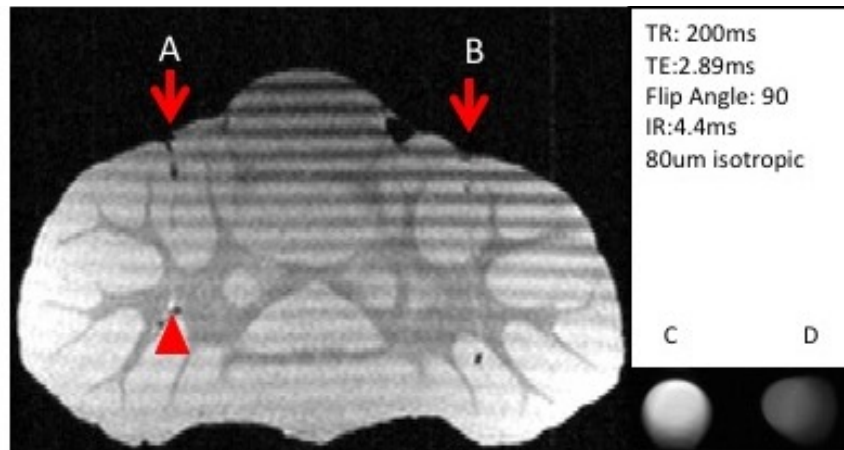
Ex vivo MRI of fixed HEK cells injected in to post mortem tissue. HEK cells expressing OATP (A) and infected with sham virus (B) were incubated in Primovist, before being fixed, washed and then injected in to a pre fixed cerebellum. The cerebellum was then imaged, ex vivo, as previously described. The syringes containing remaining cells were simultaneously imaged (C-expressing OATP, and D infected with sham virus, and therefore not expressing OATP) as a control. The injection tracts can be seen in both A and B, and contrast enhancing cells can be seen (red triangle, below the A injection tract. Distal to the B injection tract a hypo intensity can also be seen, this is likely to be the non expressing cells which do not contrast enhance.
